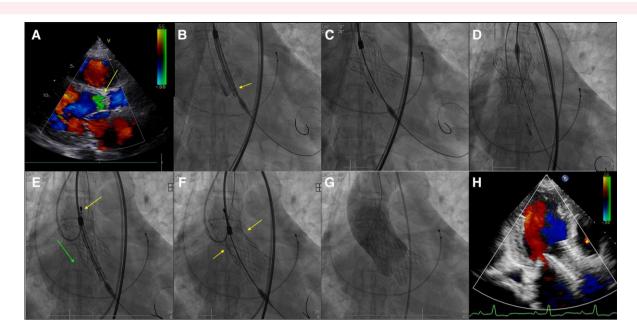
(*A*) Transthoracic echocardiography on admission showing severe aortic regurgitation in diastole; (*B*) the marker point of the valve was slightly higher than that of the non-coronary cusp plane; (*C*) position of the first valve after deployment; (*D*) the entire valve jumped up to the ascending aorta; (*E*) the passage of the ablation catheter through the mesh of the valve (yellow arrow) and pushing of the valve to the sinus of Valsalva (green arrow); (*F*) the corolla of the second valve was anchored at the narrowest part of the first valve; (*G*) angiography at the end of the procedure. (*H*) Result of the post-procedural transthoracic echocardiography.
